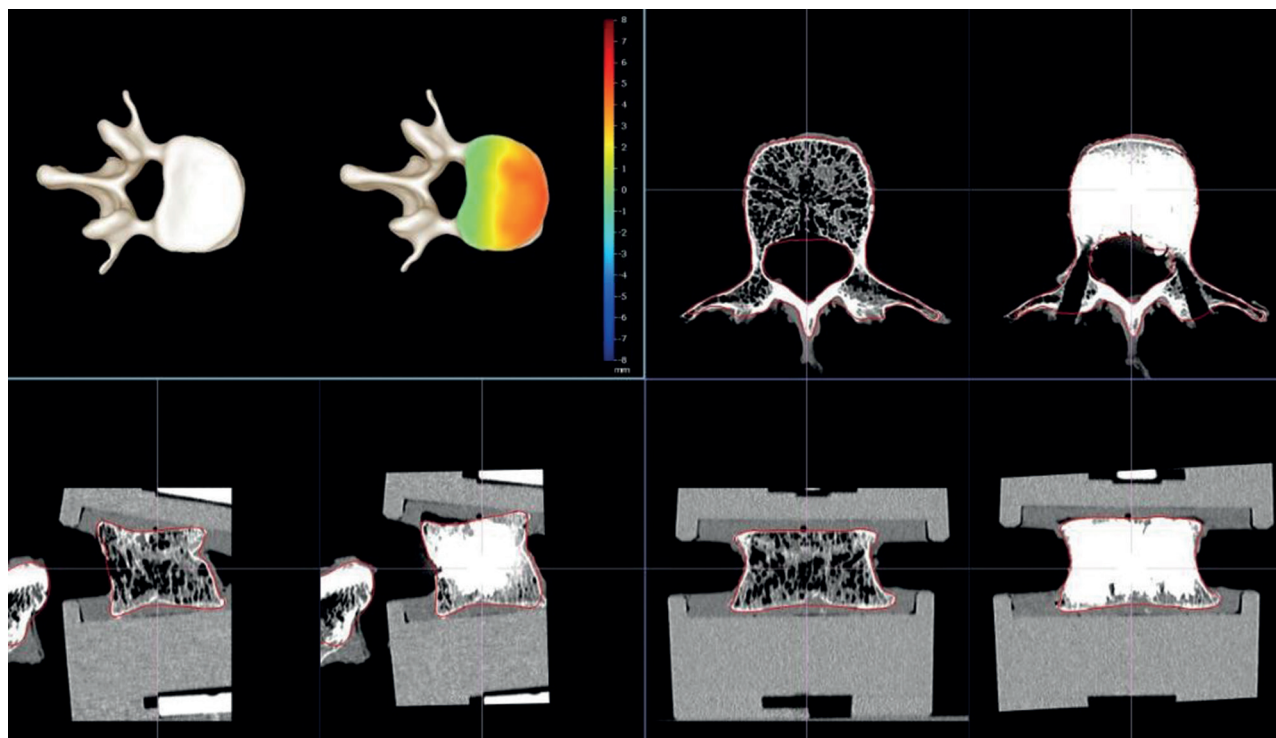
Preoperative and Postoperative CT scans of the vertebra used in a biomechanical test, giving evidence of the anterior height restoration, and the 3D mapping showing restoration of the superior endplate
